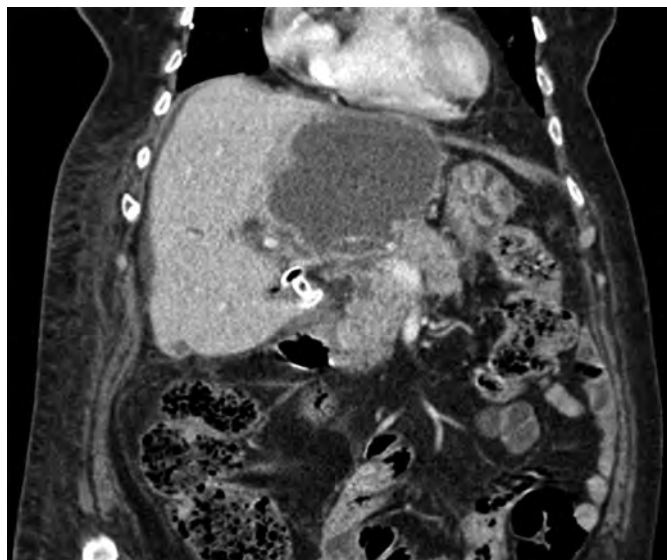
Hepaticoduodenostomy on abdominal CT.
